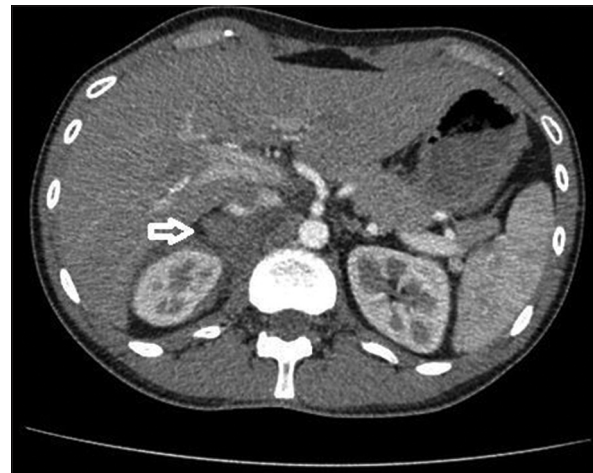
CE-CT follow up scan, one month after discharge shows reduction in adrenal hematoma size, with no active contrast agent extravasation
